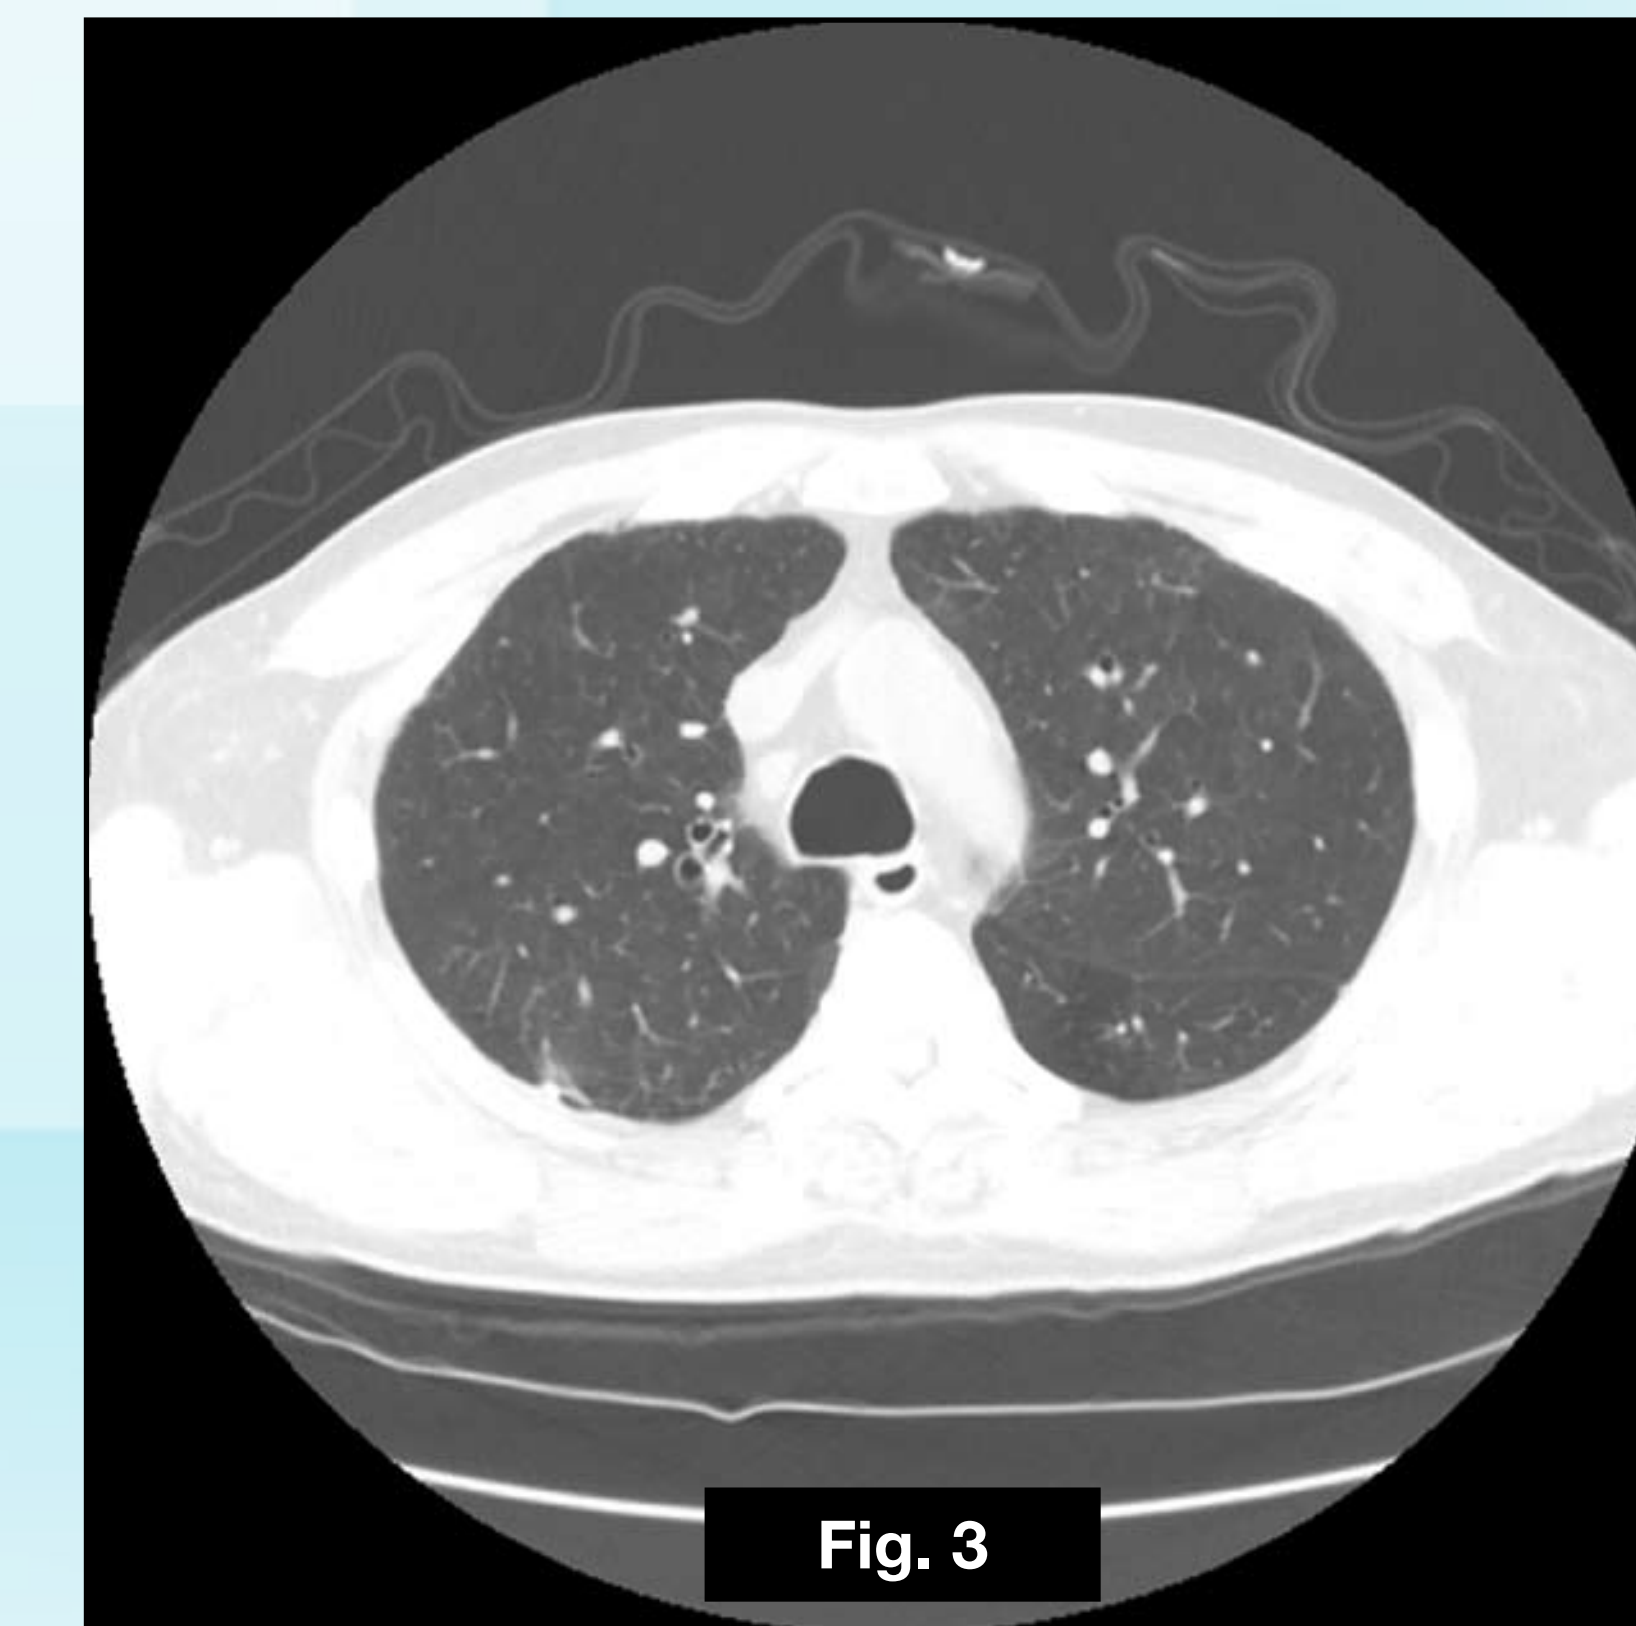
CT of Chest showing resolution of bilateral ground-glass opacities after 10 weeks.
